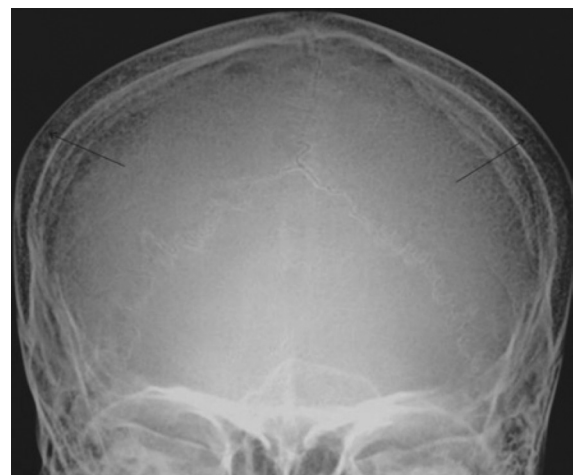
X-ray skull showing increased marrow proliferation with thin cortical bone margins
